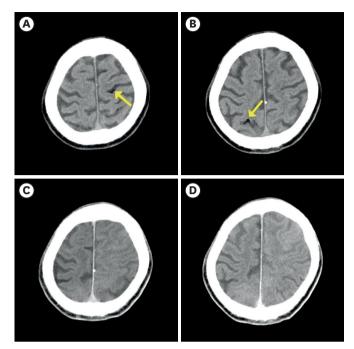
Initial and follow-up brain CT image.
